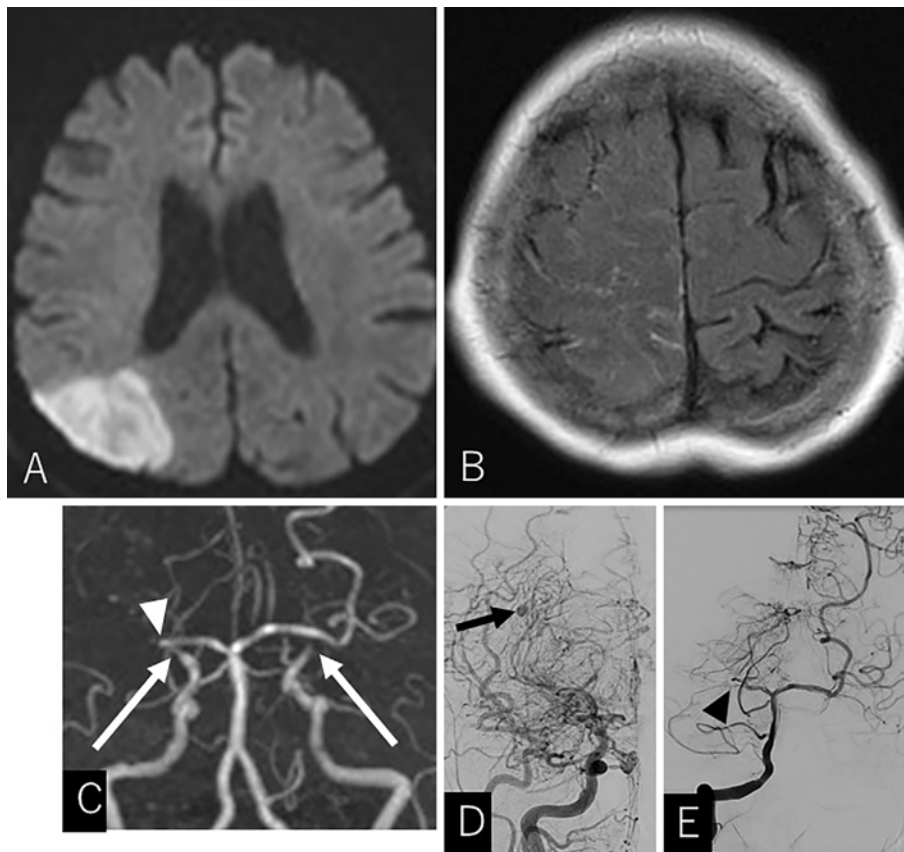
A) DWI of the head shows cerebral infarction from the right parietal lobe to the right occipital lobe. B) On FLAIR imaging, linear hyperintensities of the sulci are evident in the right cerebral hemisphere. C) MRA shows occlusion of the terminal portions of the bilateral internal carotid arteries (white arrows) and right PCA (white arrowhead). D) Angiography of the right internal carotid artery shows steno-occlusive changes at the terminal portion of the internal carotid artery and moyamoya blood vessels at the base of the brain. Micro-aneurysm is observed at the periphery of the lenticulostriate artery (black arrow). E) Angiography of the right vertebral artery shows occlusion of the PCA (black arrowhead).
